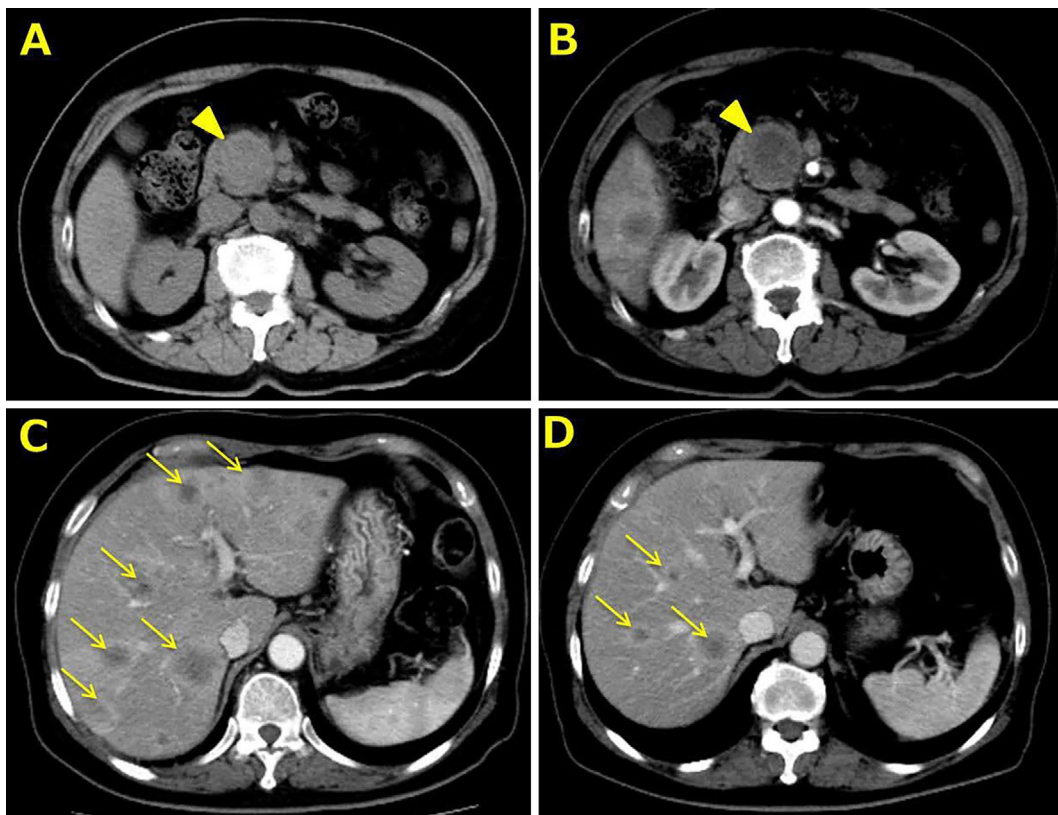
Intravenous contrast-enhanced computed tomography of the abdomen at the time of the diagnosis of pancreatic carcinoma (A, plain; B, arterial phase; C/D, portal phase). A low-density mass was detected in the head of the pancreas (A/B, arrowhead). Low-density masses in the liver were recognized as multiple metastases (C/D, arrow).
